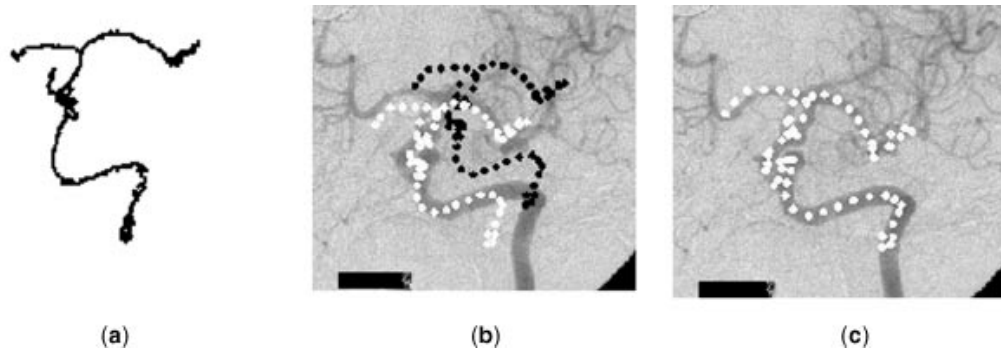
Example of 3-D-2-D feature-based registration: (a) 3-D skeleton of a 3-D MRA segmentation scan like Fig. 1(b); (b) initial approximate alignment (white dots) of projected 3-D skeleton model (black dots) on 2-D X-ray view; (c) best-fit 3-D-2-D registration of projected model to image data (45).
